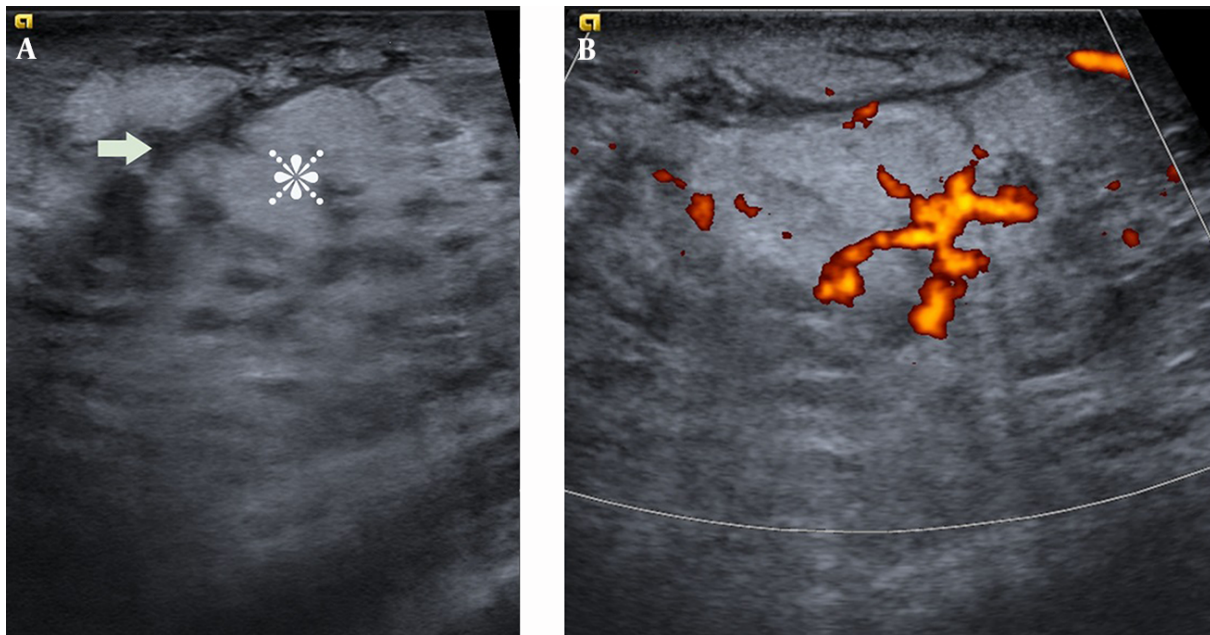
A, B-mode US image showing ill-defined hyperechoic lesions (star) including finger-like hypoechoic areas (arrow) classified as BI-RADS 3; B, Power Doppler image showing increased Doppler flow within the lesion.
